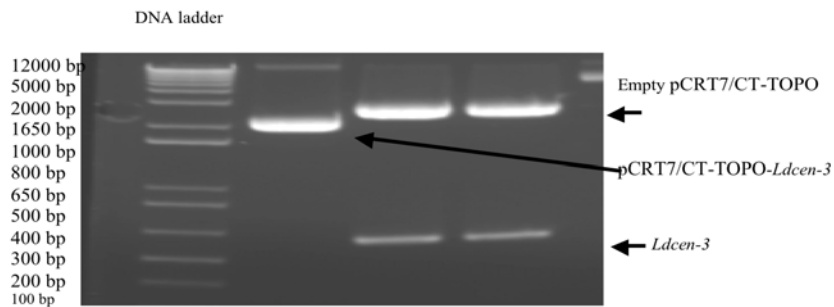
subcloning of Ldcen-3 into pcDNA 3.1 (-) vectors: pCRT7/CT-TOPO-Ldcen-3 was cut by XbaI and Hind III restriction enzyme 1- ladder; 2- pCRT7/CT-TOPO-Ldcen-3, 3,4-the above band is a linear empty pCRT7/CT-TOPO and lower band is Ldcen-3.
